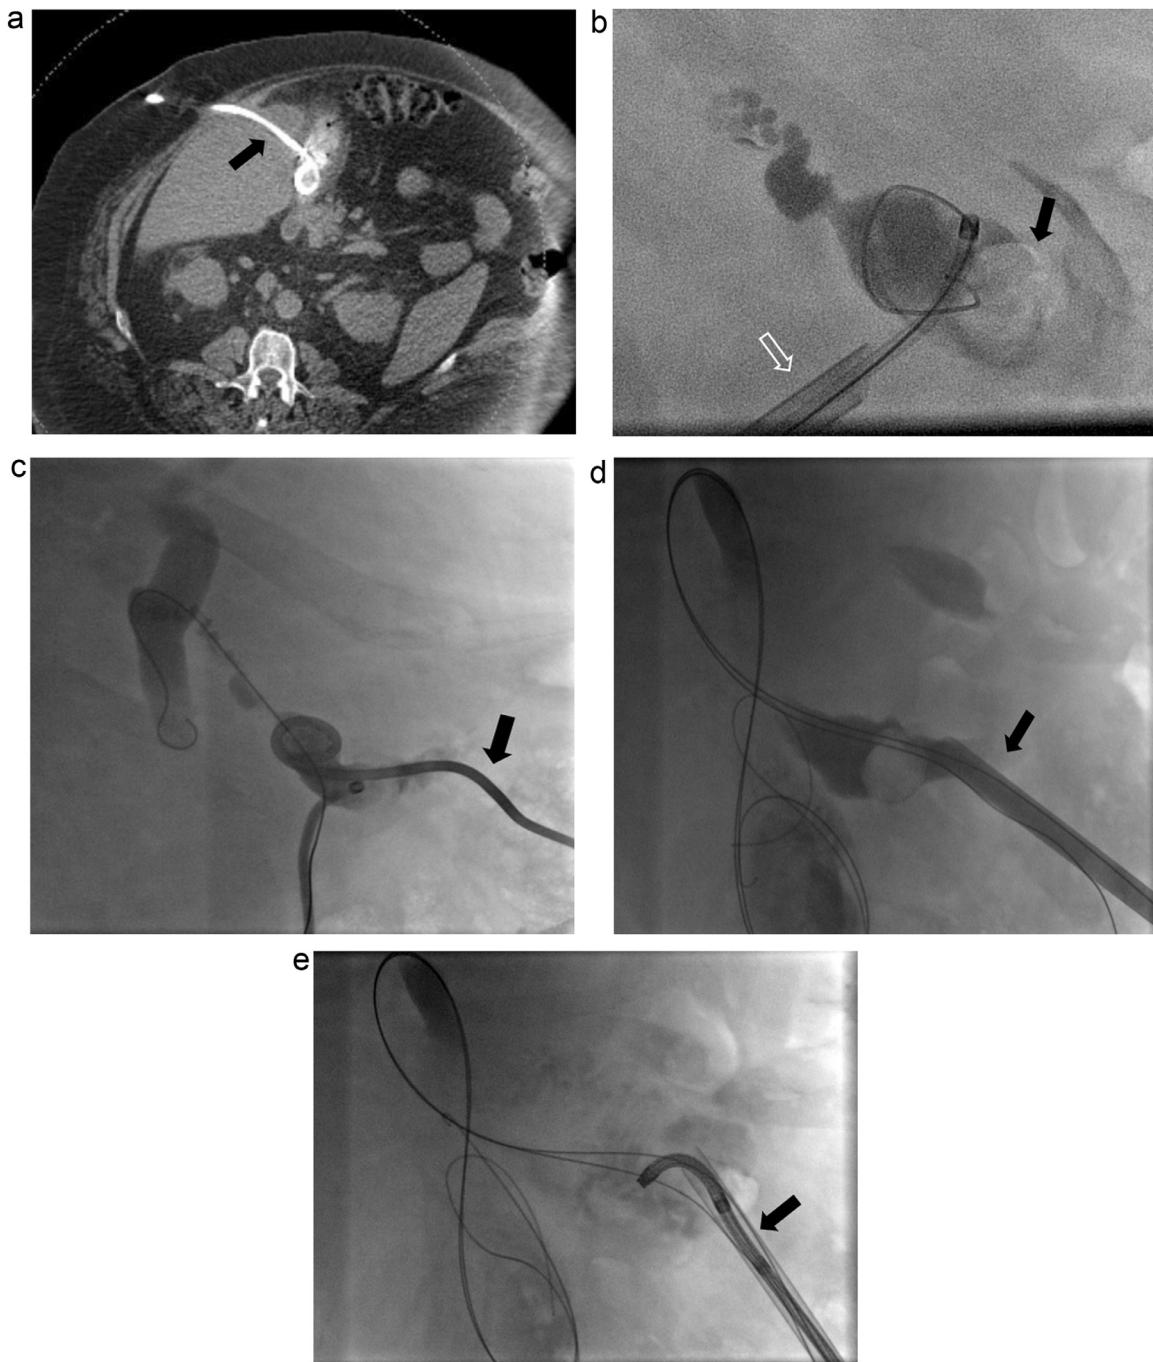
56-year-old man with gallstones and multiple comorbidities including morbid obesity. (a) CT shows a cholecystostomy catheter (arrow) with transhepatic access into the lower body of gallbladder. (b) Cholangiogram shows a large stone (arrow) in the fundus of the gallbladder. A 24F 17 cm (open arrow) sheath was too short to get into the gallbladder lumen due to his body habitus. (c) A new cholecystostomy catheter (arrow) was placed into the gallbladder. A new access was obtained to left side of abdomen because his abdomen had shifted to left side due to morbid obesity (d, e) About 10 weeks later, after successful placement of a 24F 17 cm sheath (arrow) into the gallbladder, a gallstone was successfully removed using cholecystoscopy (arrow) with EHL probe.
